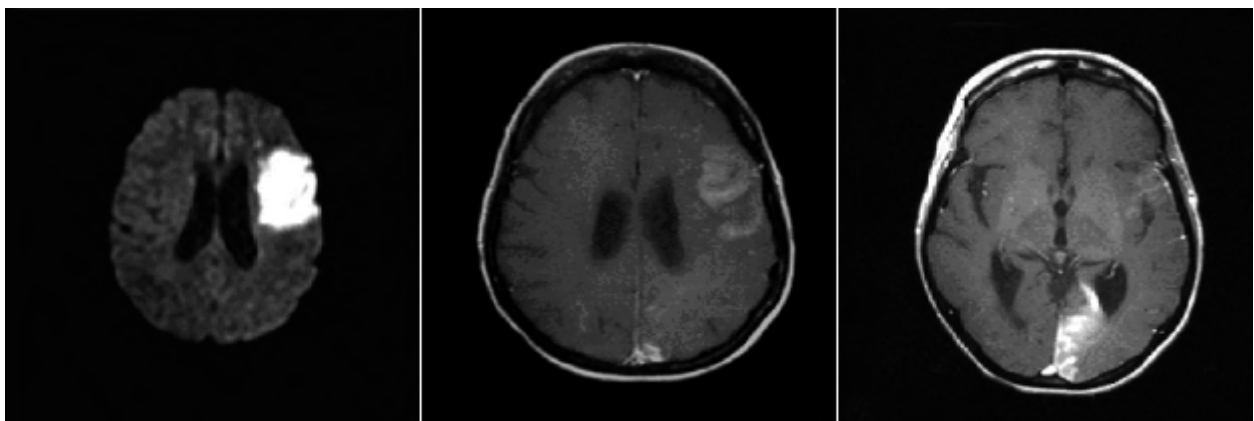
Representative magnetic resonance images demonstrating extensive infarctions in the left parietal and occipital lobes
